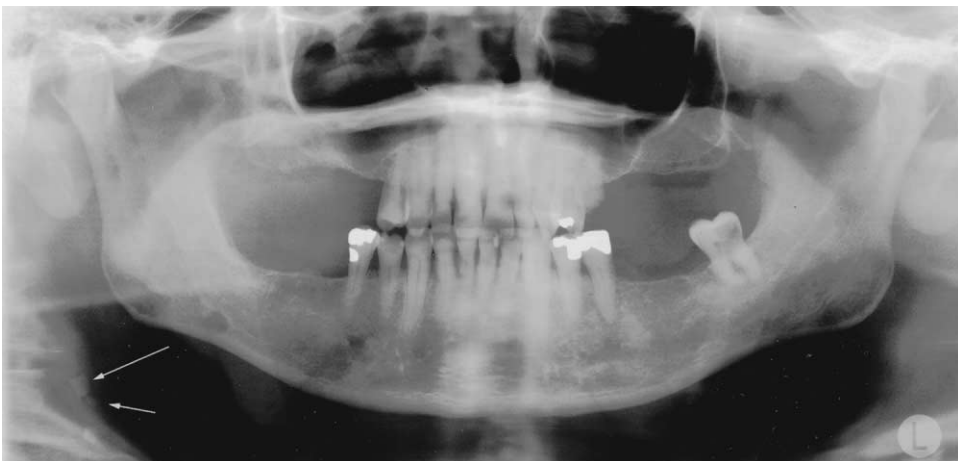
Panoramic radiograph demonstrating calcifications within the carotid artery. Two calcifications are identified by the white arrows.
